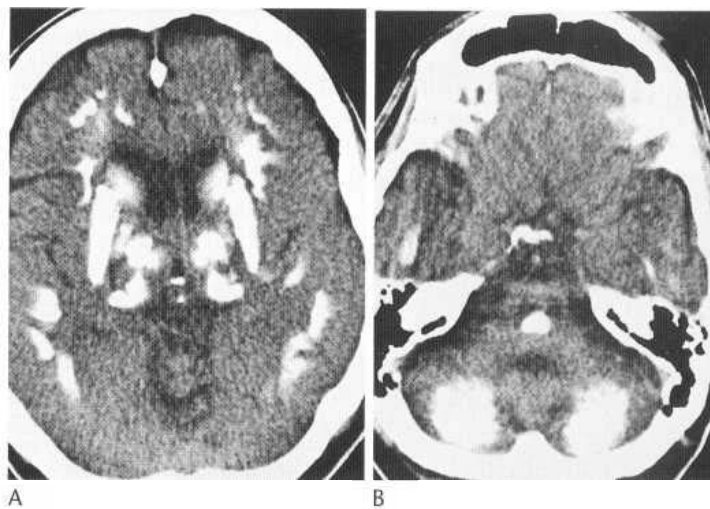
Axial CT scans demonstrating extensive calcification in the basal ganglia, thalami, subcortical white matter, brainstem and dentate nuclei of the cerebellum in Fahr's syndrome.
